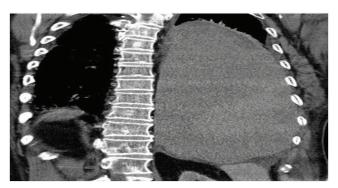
Computed tomographic scan shows mixed high-density pleural fluid accumulation in the left lung.
